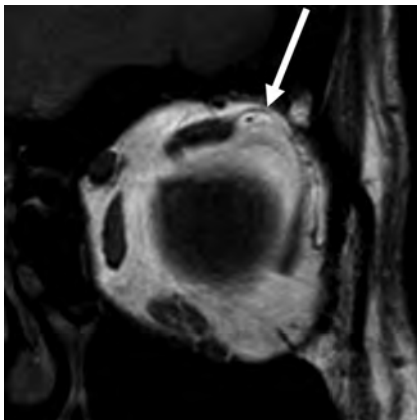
LR-SR band bowing in a 54-year-old woman. Coronal T1-weighted image of the left orbit shows superior bowing of the LR-SR band (arrow), higher than the upper margin of the superior muscle complex.
